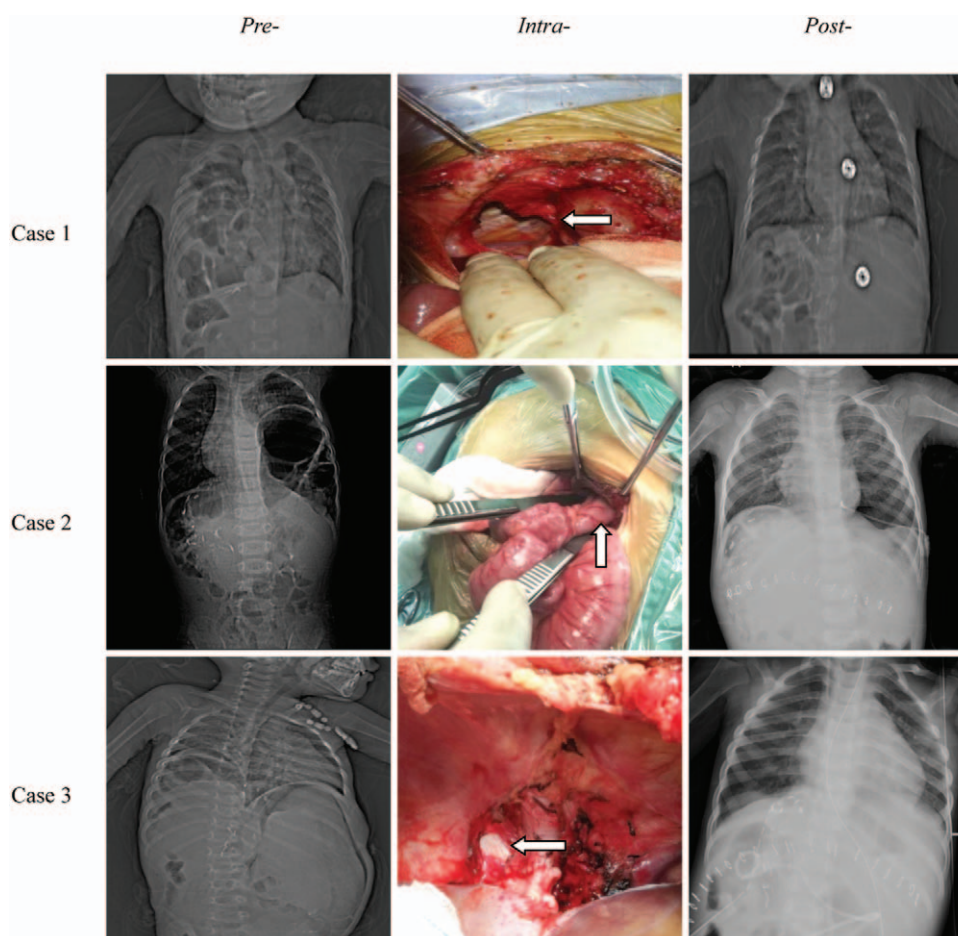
Chest computed tomography scan or x-ray of the patients pre-, intra-, and post-repair operation of DH (case 1 and case 3 were both right DH and case 2 was left DH). 1. Arrows head the position of DH intra-operation. 2. Words on the top of the columns means the time of images. 3. Words on the left of the rows means the order of patients.
